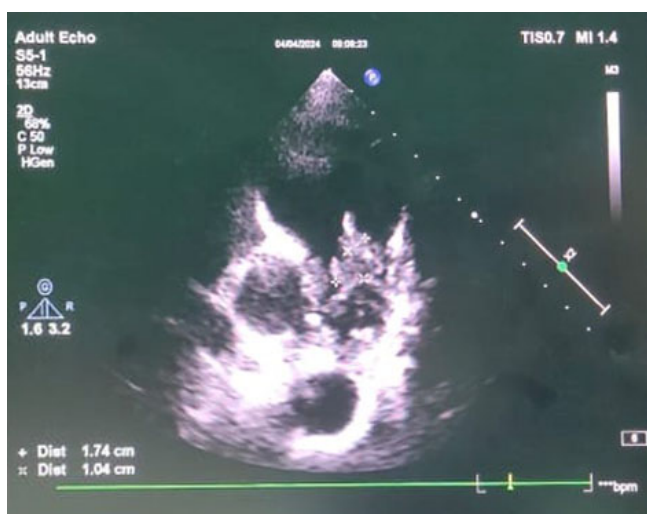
Vegetation Finding with Transthoracic Echocardiography
